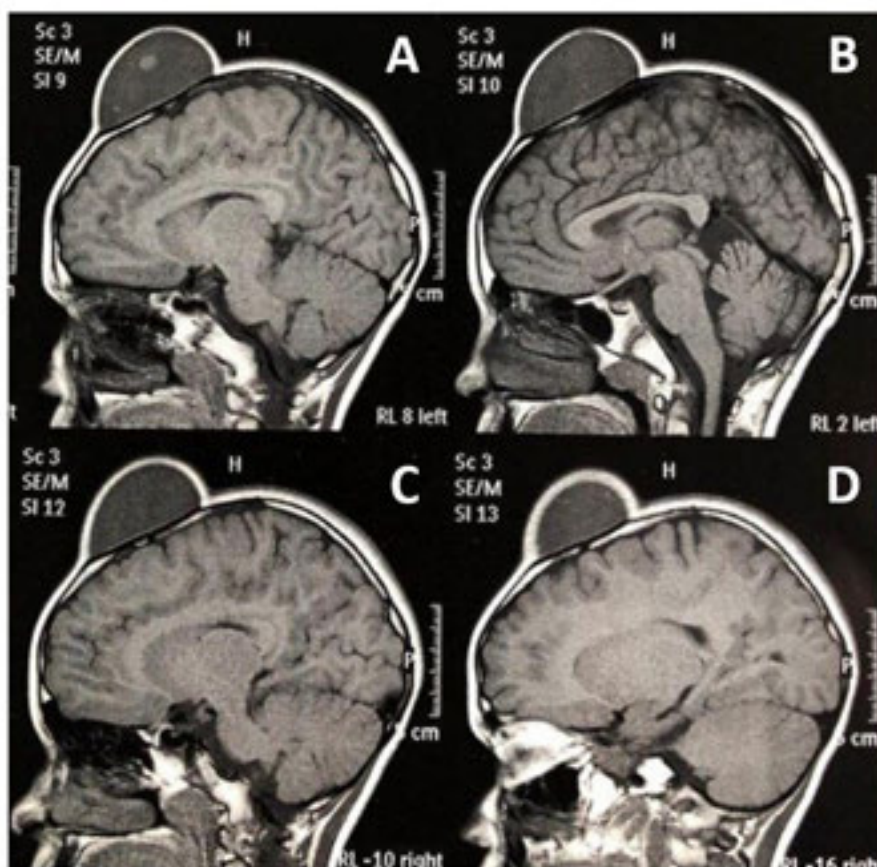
A-D. Cranial Magnetic Resonance Imaging (MRI) revealing a well-defined, midline frontal subgalea cystic expansive lesion, hypointense on T1-weighted imaging, measuring $60 \times 60 \times 32$ mm, located at the anterior fontanelle (Bregma).
